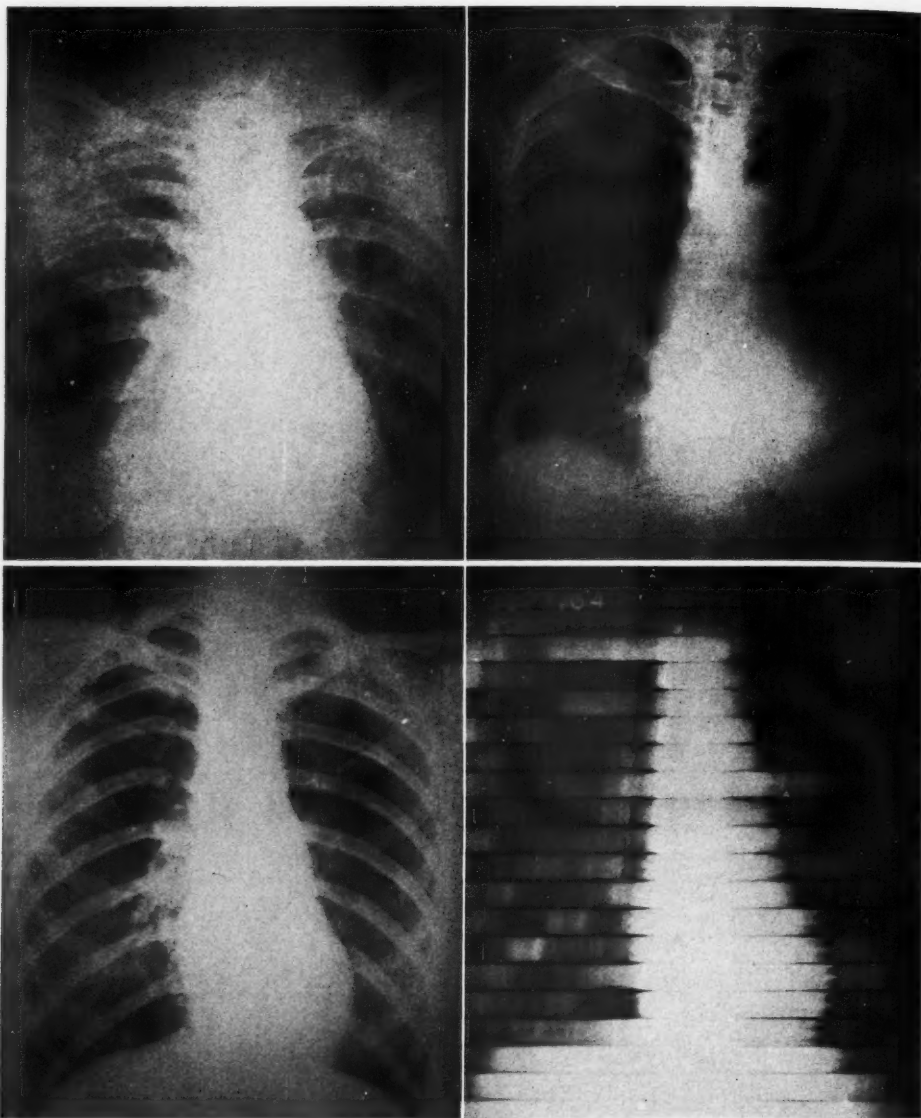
(*upper left*). Aortic insufficiency may be a cause of anginal attacks. Note the marked increase in the length of the heart due to dilatation of the left ventricle. Typical "water-hammer" pulsations are observed roentgenoscopically.
